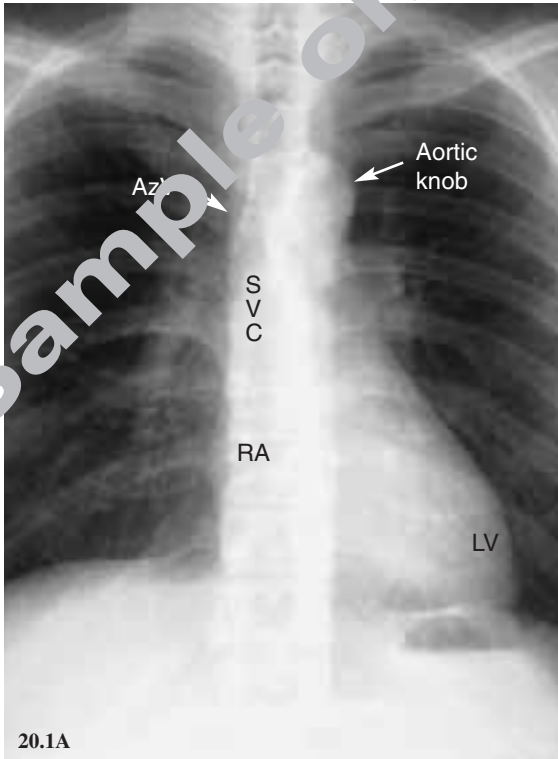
Chest radiographs in various projections. (A) Posteroanterior view. (B) Lateral view. (C) RAO view. (D) LAO view. (Key: SVC: superior vena cava, AzV: azygos vein, IVC: inferior vena cava, RA: right atrium, RAA: right atrial appendage, RV out: right ventricular outflow tract, PA: pulmonary artery, LA: left atrium, LV: left ventricle, AA: ascending aorta).
